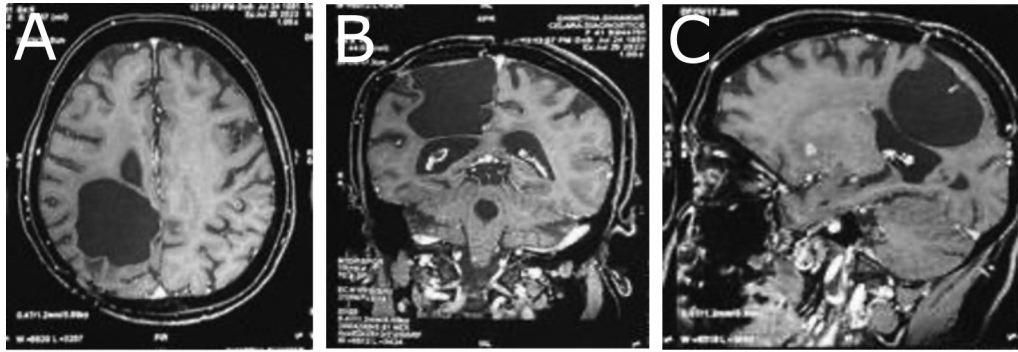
Five-year postoperative contrast magnetic resonance imaging (MRI) images of the patient's brain, axial (A), coronal (B) and sagittal (C), showing the excision cavity with absolutely no enhancement of the wall or surrounding tissue, indicating no recurrence.
